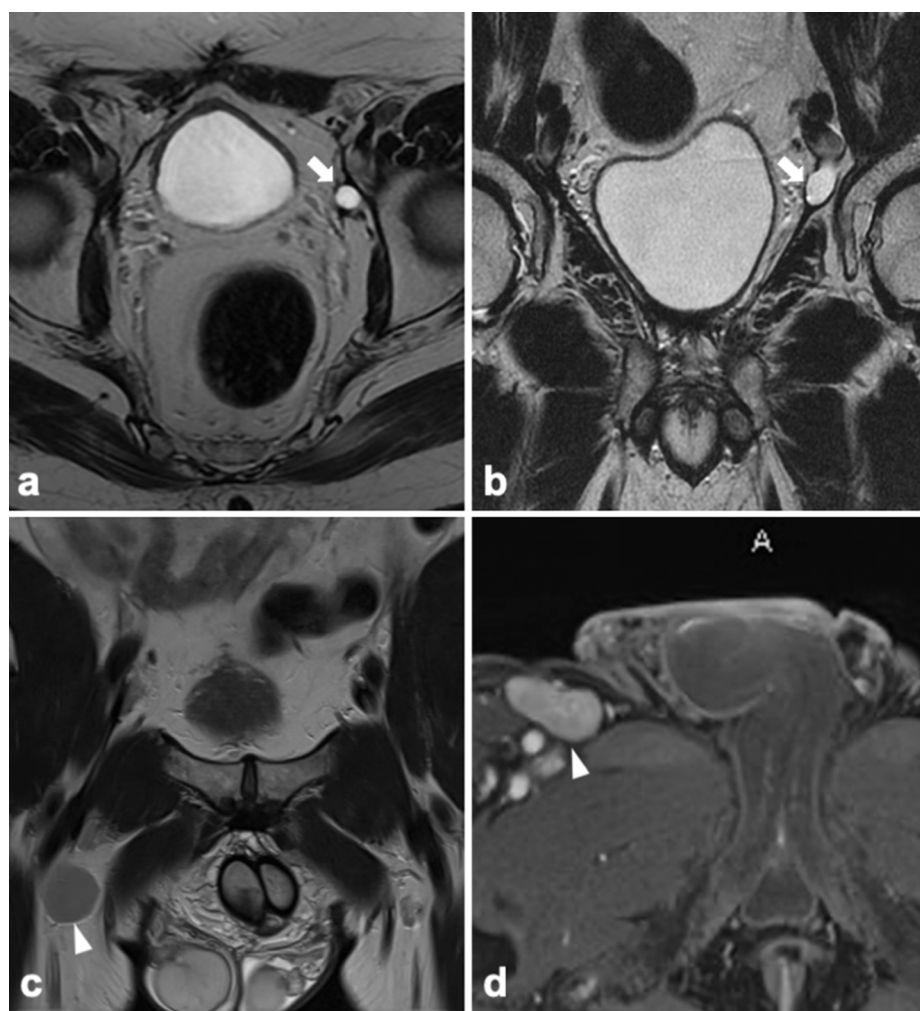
Axial (a) and coronal (b) T2w images show a small left external iliac capsulated fluid collection (arrows), consistent with lymphocele in a patient underwent radical prostatectomy. Coronal T2w (c) and axial post-contrast fat-sat T1w (d) images show an enlarged right inguinal lymph node (arrowheads), biopsy proven as lymphoma. T2w T2-weighted, T1w T1-weighted.
